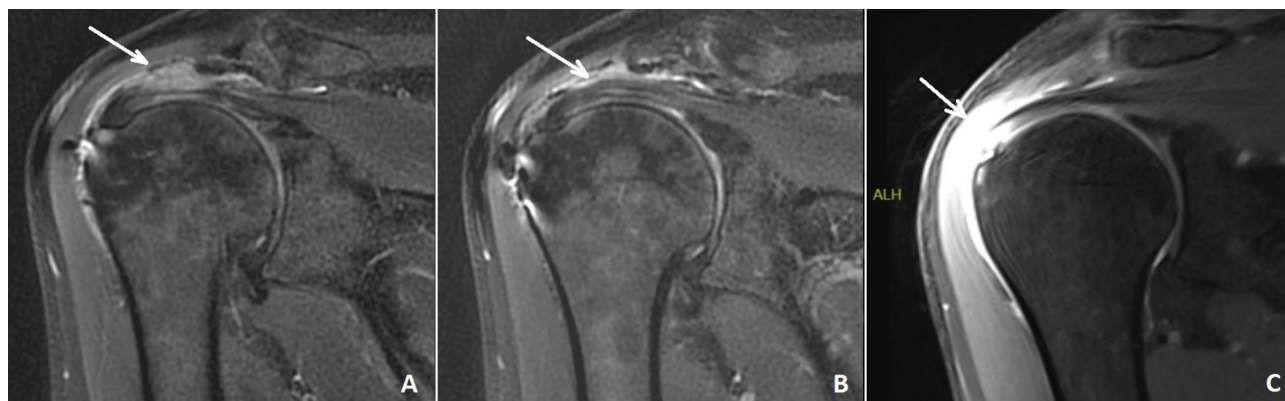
A) Coronal T2 MRI of a 55-year-old female patient interpreted as the presence of nearly complete rotator cuff rupture on the right shoulder (arrow: nearly complete rotator cuff rupture); B) Another coronal T2 section of the same patient, complete rupture of the supraspinatus was not detected in this patient's operation, rotator cuff repair was not performed (arrow: stable supraspinatus tendon); C) Coronal T2 MRI of a 49-year-old female patient interpreted by radiologists as the presence of distal full-thickness supraspinatus rupture. No rotator cuff rupture was detected in this patient (arrow: tendon attachment site cannot be distinguished).
